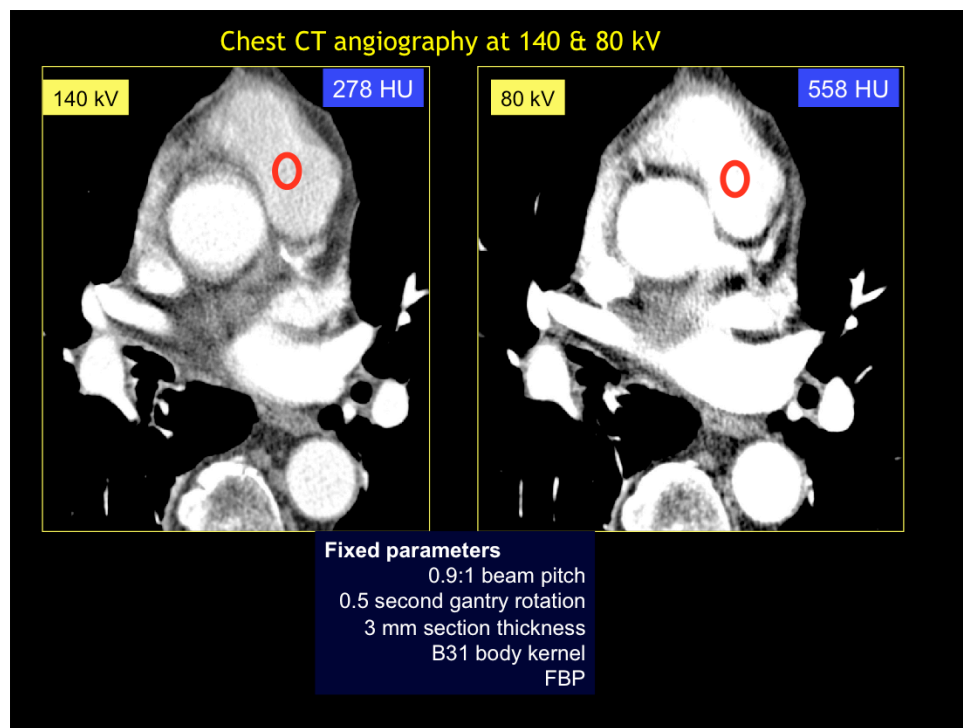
Chest CT angiography performed at varying 140 and 80 kV. Lowered kV (80 kV) shows incre
